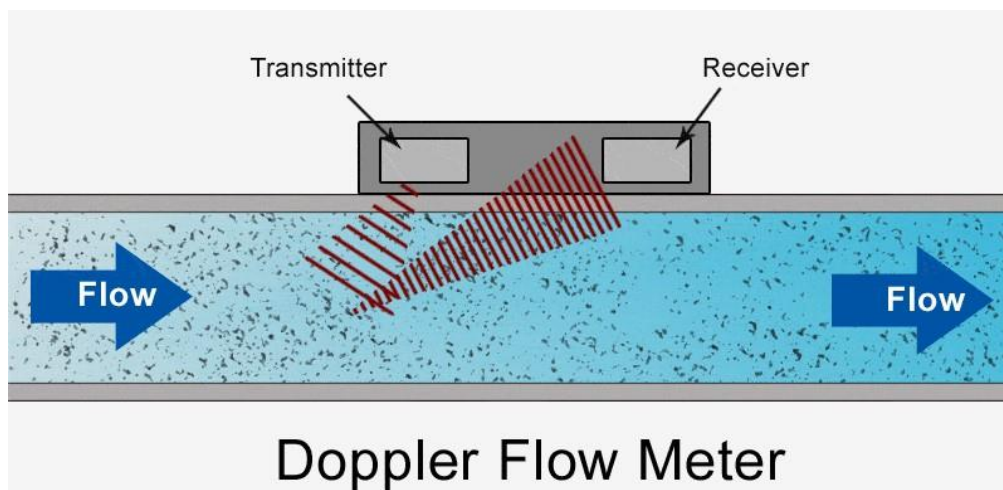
Laser Doppler flowmeter set up(Patrick Mullins, 2016)
